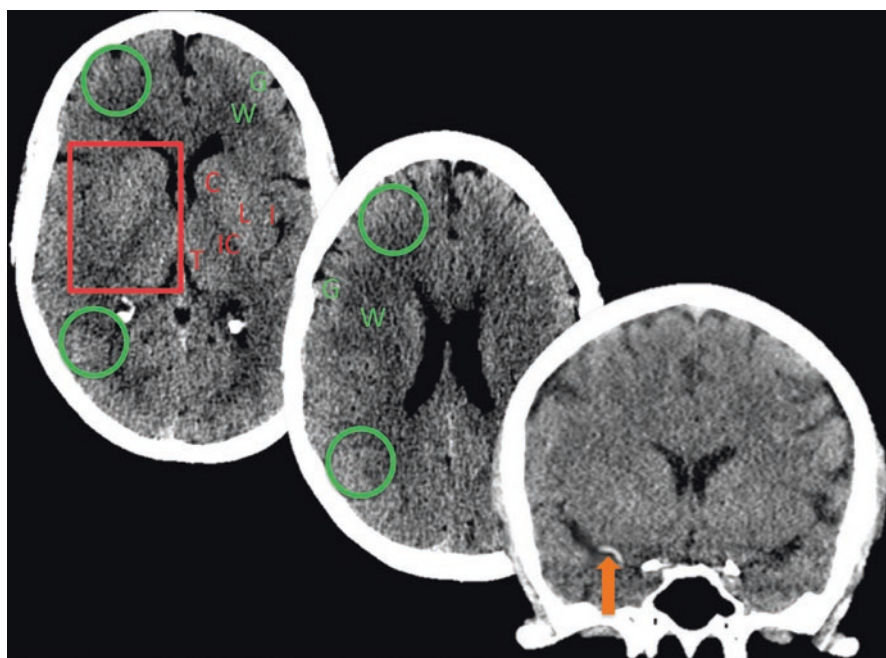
Relevant non-contrasted CT images for Case 2. The axial images (left and middle) reveal normal appearing brain tissue. *G* gray matter, *W* white matter, *C* caudate head, *L* lentiform nucleus, *I* insula, *IC* internal capsule, *T* thalamus. *Green circles* intact gray white differentiation, *red box* intact distinctions of the basal ganglia. The coronal image on the right displays a hyper dense right middle cerebral artery (*orange arrow*) which is suggestive of acute clot
